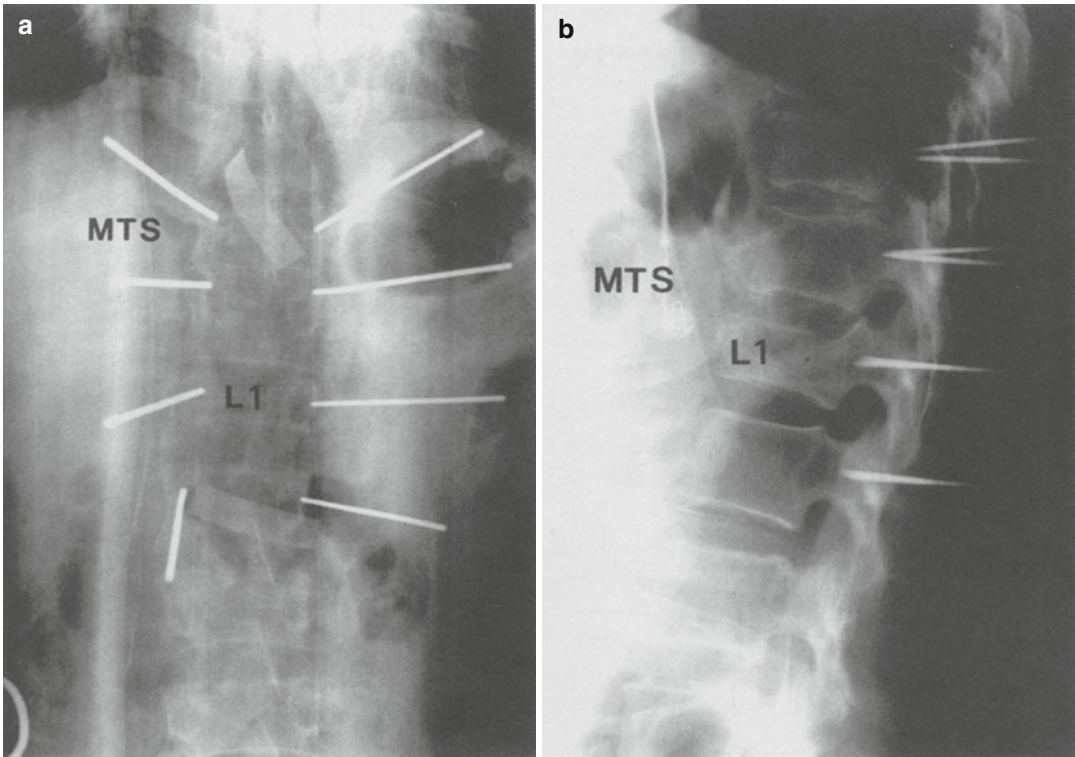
Intraoperative roentgenogram. (a) PA roentgenogram. (b) Lateral roentgenogram
